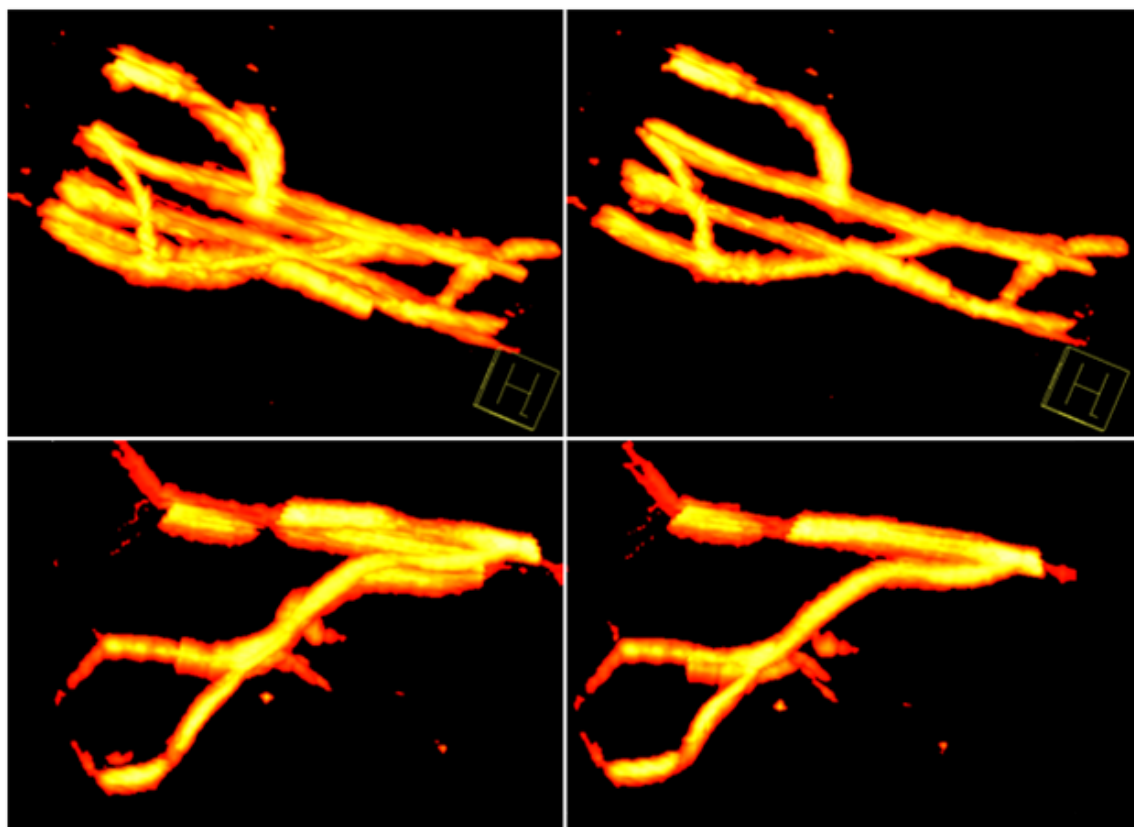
Result of simultaneous registration of multiple Power Doppler volumes for two test data set configurations. Left column: Alignment after application of calibration transformations to individual volumes. Right column: Alignment after simultaneous registration with distance-based similarity metric. The improved alignment is clearly visible for both cases.
